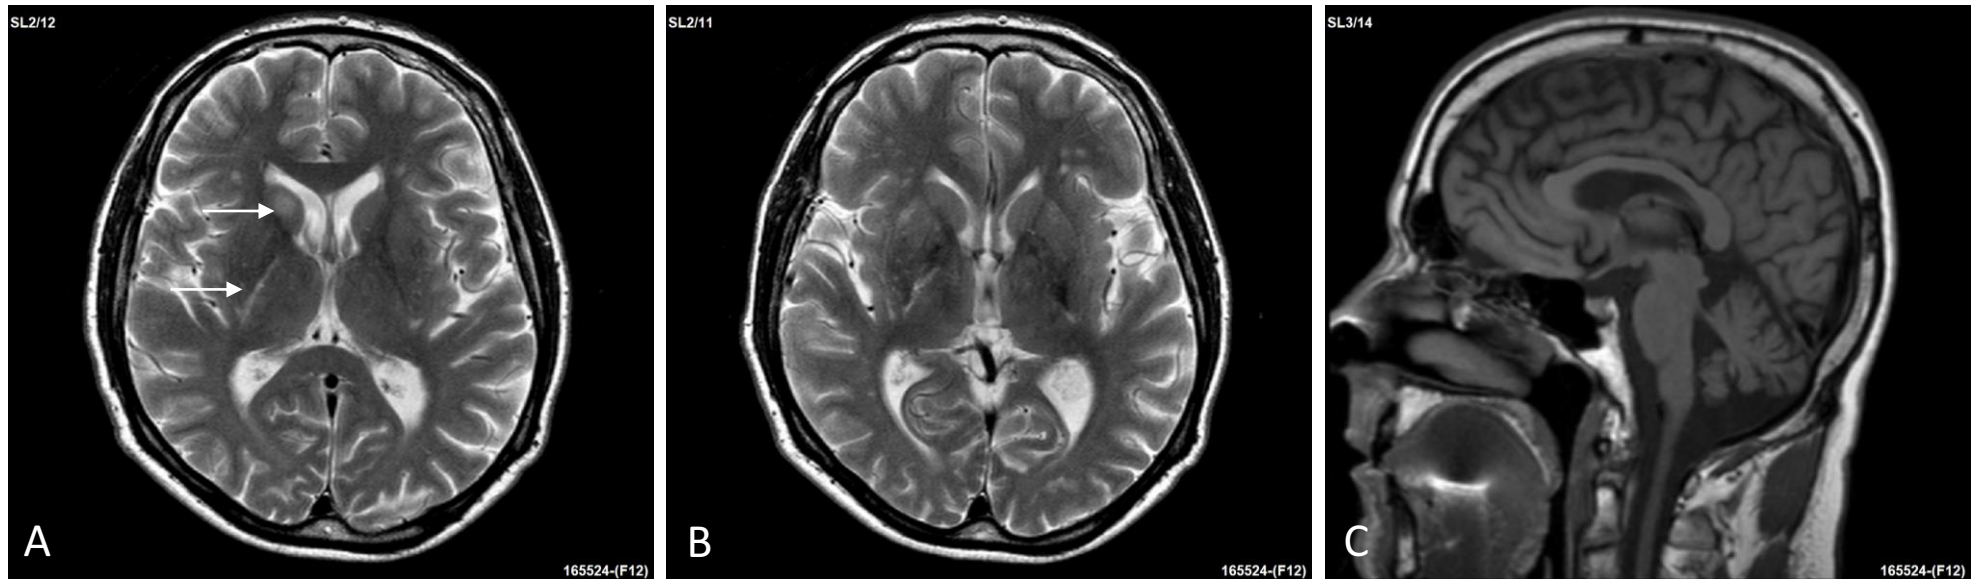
Brain MRI of patient with m.8719G>A mutation in MT-ATP6 gene at the age of 43. Axial T2-weighted images show a hypersignal lesion in the right caudate and right dorsal limb of the capsula interna (arrows, A). In addition, nonspecific small hypersignal foci in the white matter and mild cortical atrophy are present (A, B). Sagittal view of the T1-weighted image also shows mild cerebellar atrophy (C).
